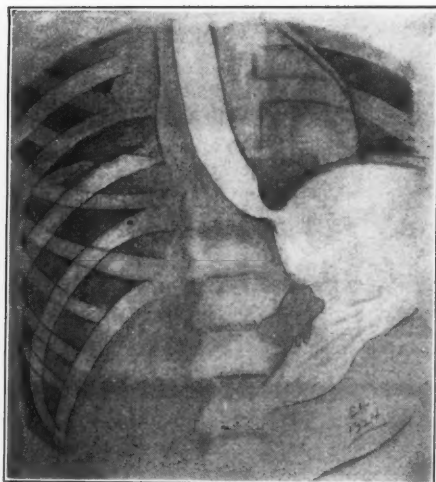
Retouched tracing from X-ray film. Adult. The film was taken in full inspiration.
